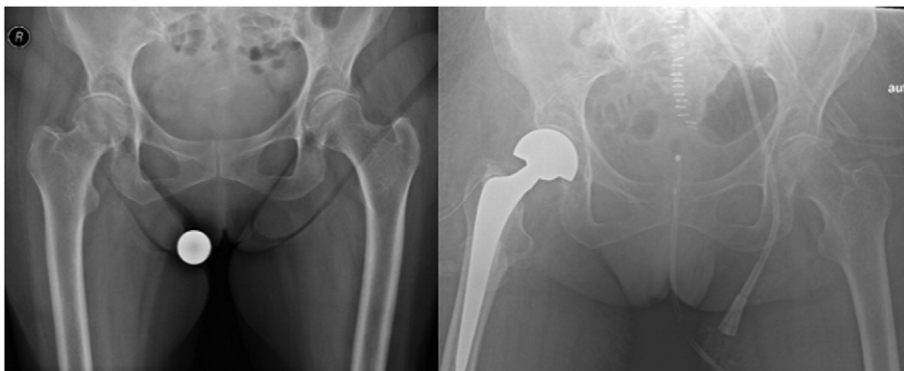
Pelvic X-ray of the patient pre- and postoperatively.
